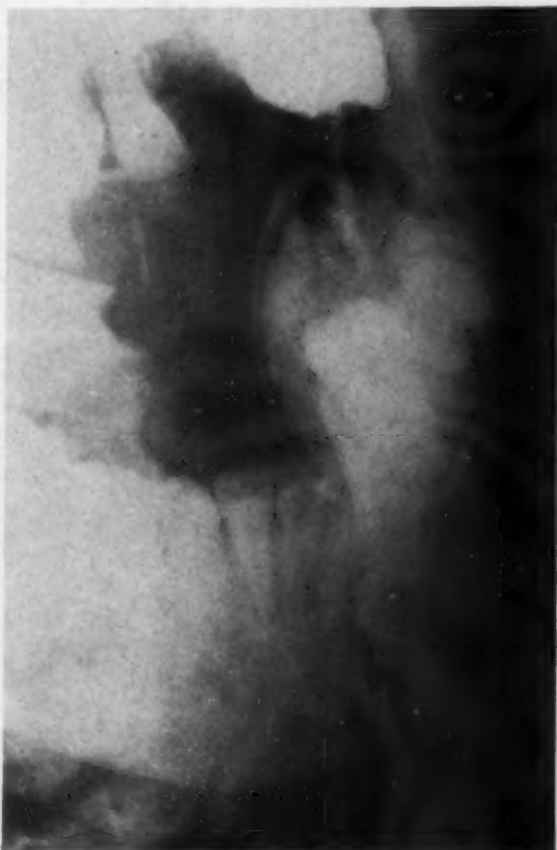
Roentgenogram of left mandible showing lingual expansion of tumor mass with exceedingly thin lingual bony plate (Pl. 8312).
